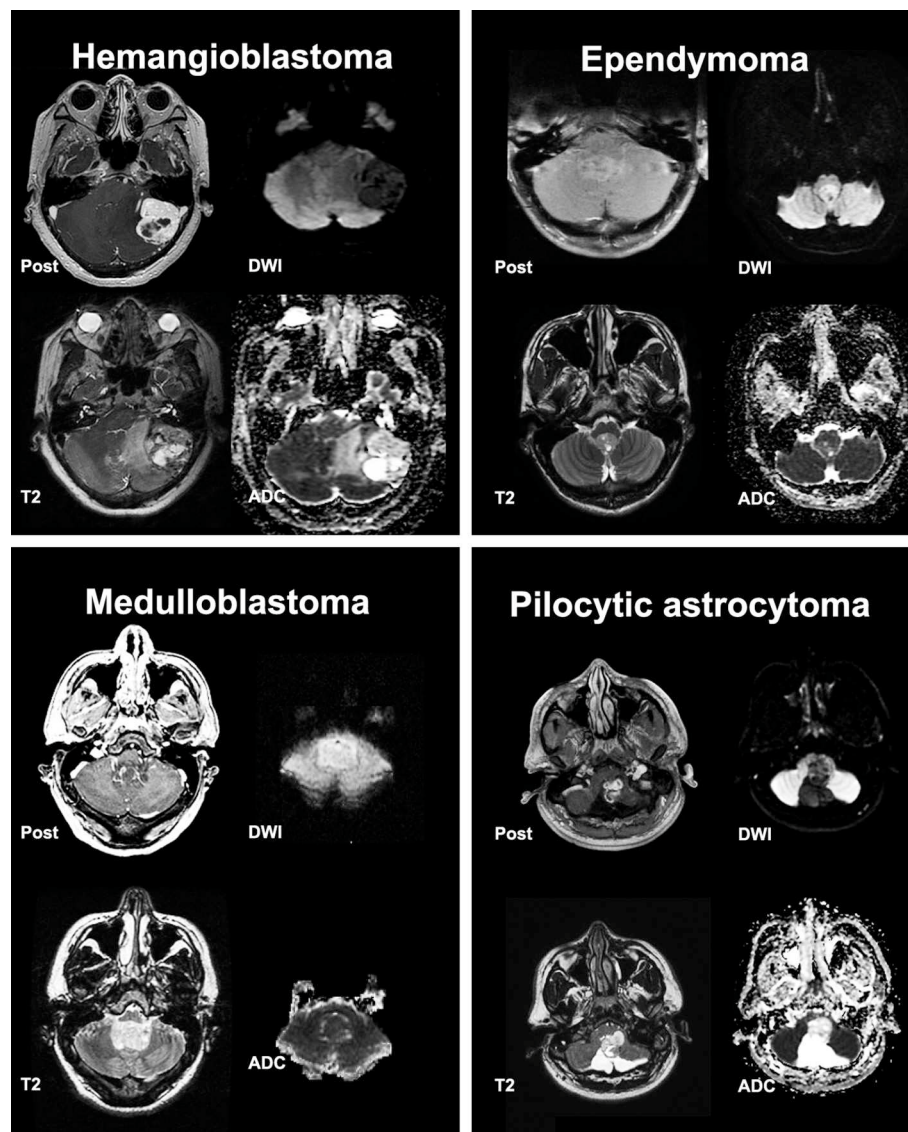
Post contrast T1, T2, Diffusion Weighted Imaging (DWI) and Apparent Diffusion Coefficient (ADC) scans from representative posterior cranial fossa tumors.
